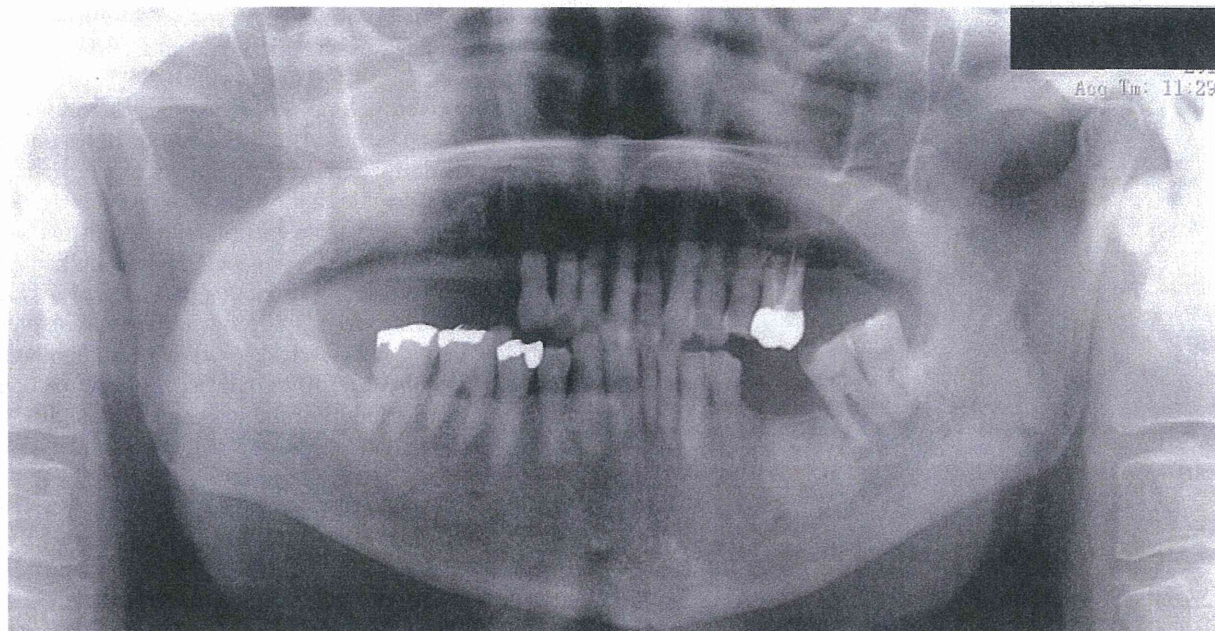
Panoramic radiograph at the initial presentation shows no deformity of the left condyle. The second and third molars of the left mandible showed periodontal disease and pathologic signs in the neighboring bone.
